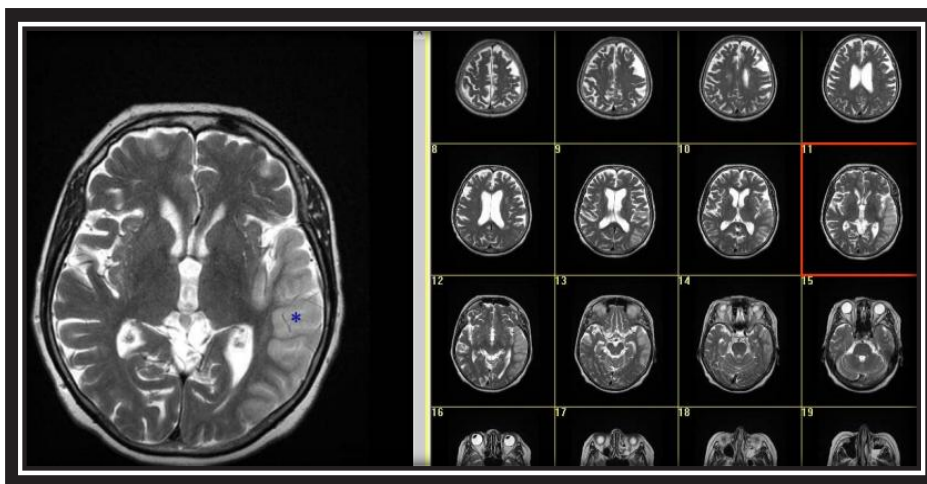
MR images of a patient with ischemia
